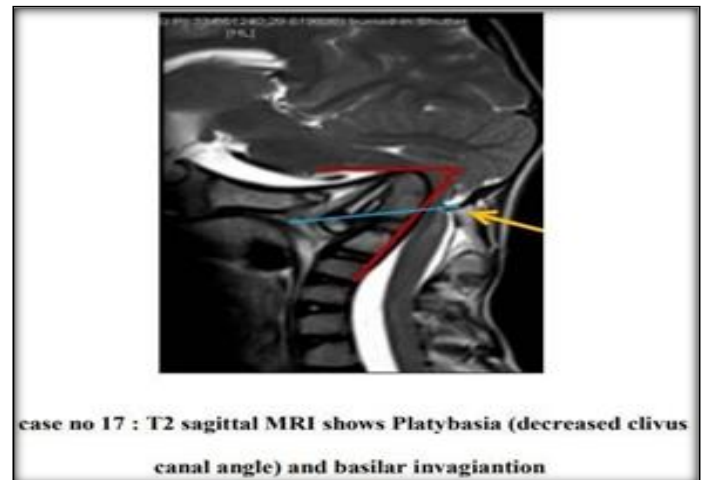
Case No. 17 — T2 sagittal MRI showing platybasia with reduced clivus canal angle and associated basilar invagination.
